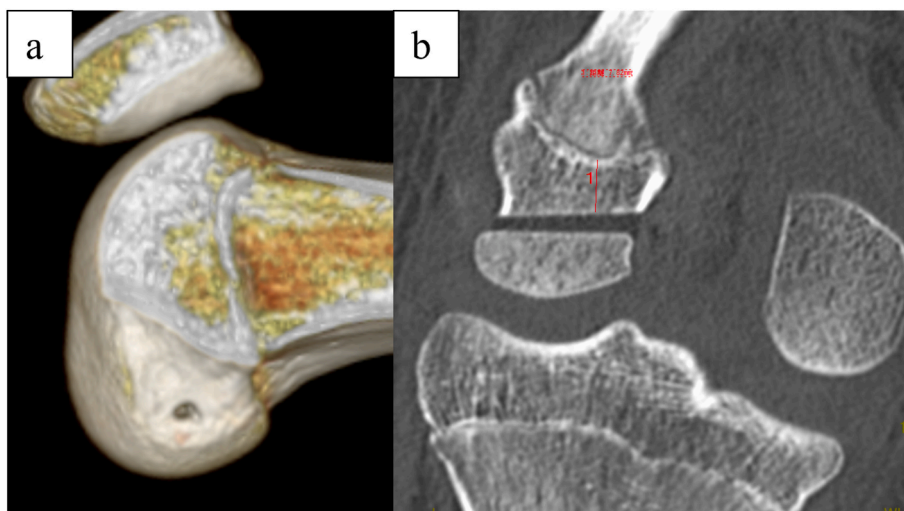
Computed tomography at three days postoperatively (A 14-year-old girl). a: Three-dimensional computed tomography: A bone tunnel could be created at the posterolateral bundle footprint. b: Adequate spacing was maintained between the bone tunnel and the physis with a distance of 7.8 mm.
